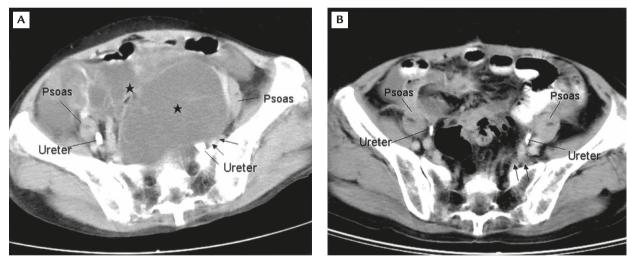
(A) Preoperative enhanced computed tomography shows a huge pelvic mass (★) with severely displaced left psoas muscle from the left ureter compared with the right side. The left internal iliac vessels and lumbosacral plexus (arrows) were also severely compressed.
